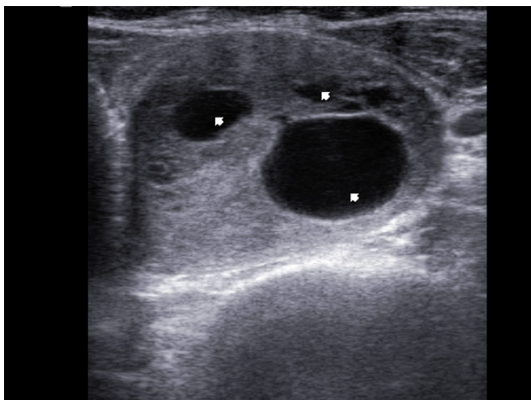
Ultrasonogram shows a large cystic hypoechoic parathyroid adenoma.
